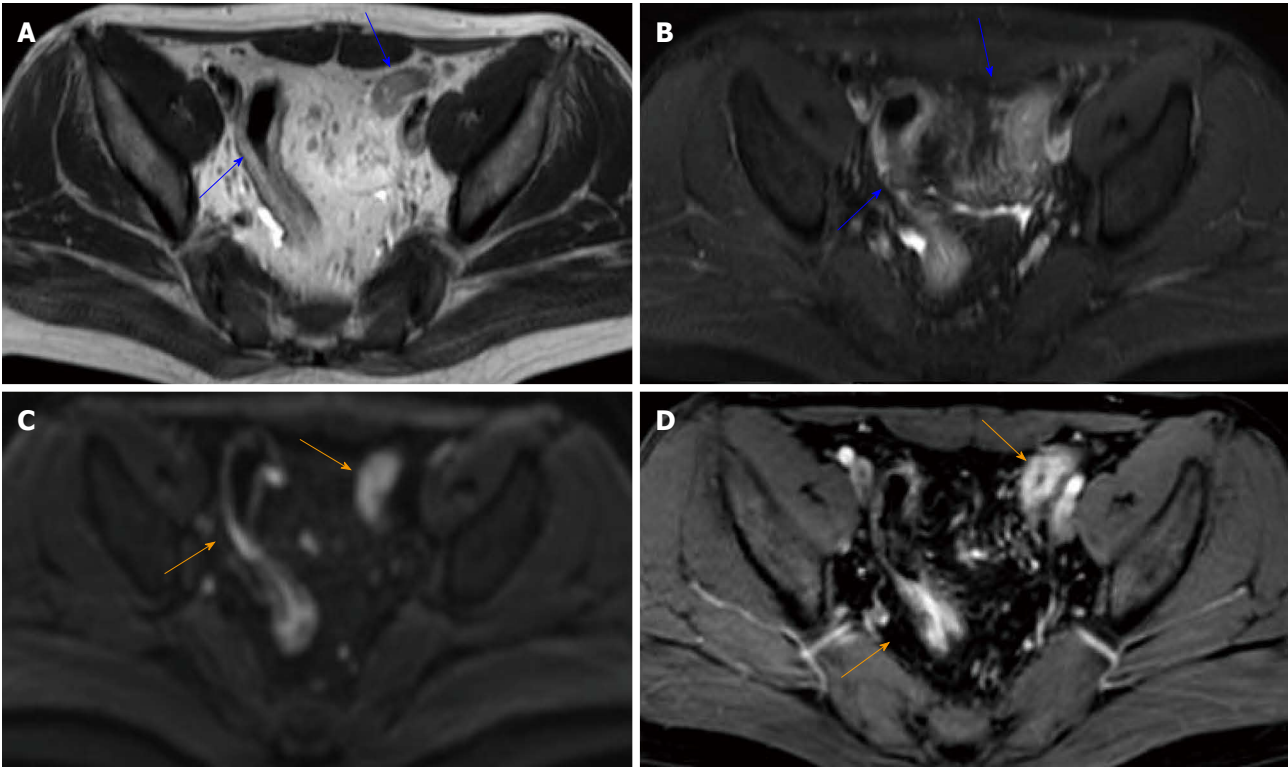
A 22-year-old woman with known ulcerative colitis involving the rectum and the sigmoid colon. Mayo index = 8; total modified Baron score = 12; total MR-score = 22; T2WI without fat saturation (A) and T2WI with fat saturation (B) show a mild thickening of the sigmoid colon wall (blue arrows); DWI hyperintensity (C; $b = 800 \text{ s/mm}^2$; orange arrows); rapid gadolinium enhancement (D; orange arrows).
